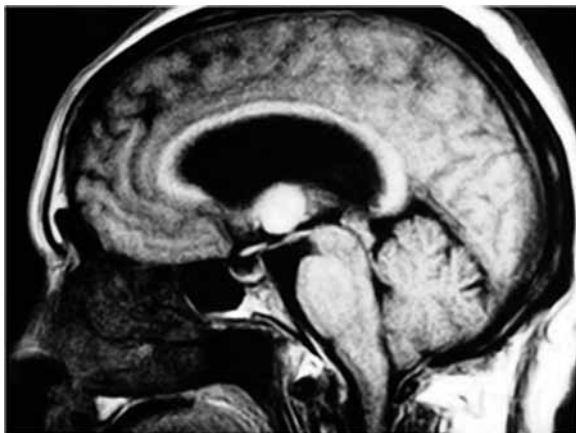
MRI showing colloid cyst of the third ventricle.
